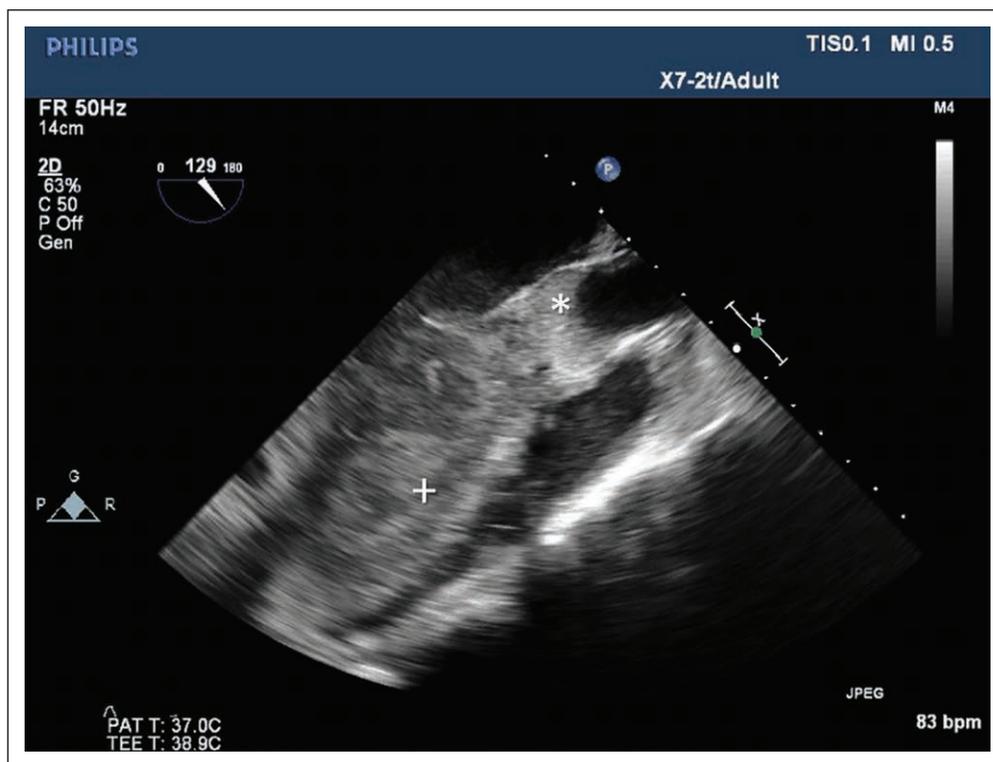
Transoesophageal echocardiogram, mid-oesophageal long axis view. The aortic valve remains closed throughout the electrical cardiac cycle. Thrombus is seen in the aortic root (*) and in the left ventricle (+). bpm = beats/min, G = general, P = penetration (imaging characteristics), PAT = patient, R = resolution, TEE = transoesophageal echocardiography.
